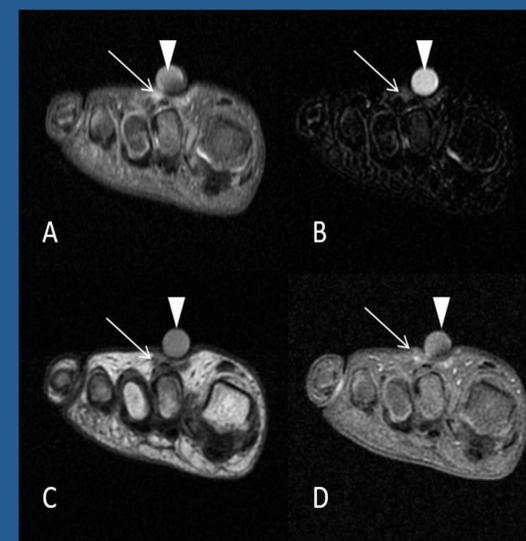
MRI of the right forefoot in the transverse plane at the level of metatarsophalangeal joints. An ill-defined subcutaneous mass of irregular shape (arrows). It is moderately hyperintense on fat-suppressed proton density (PDFS) (A) and short-tau inversion recovery (STIR) (B) images, T1 hypointense (C) with moderate inhomogeneous contrast enhancement on fat-suppressed T1 image (D). Note the compression of the lesion by a skin marker.
